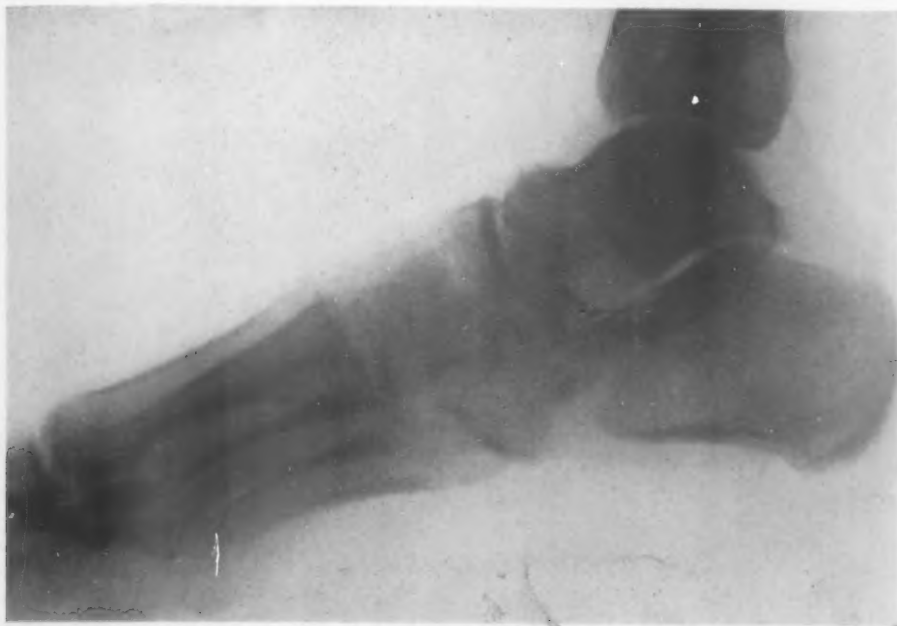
Osteoporosis of bones of foot after a slight trauma of the foot several months previous. The X-ray showed a very marked degree of decalcification of all the bones of the foot. Perifemoral sympathectomy was performed on November 26, 1926. The pain disappeared immediately and two months later a new X-ray (Fig. 15) showed a nearly complete recalcification of the bones.
